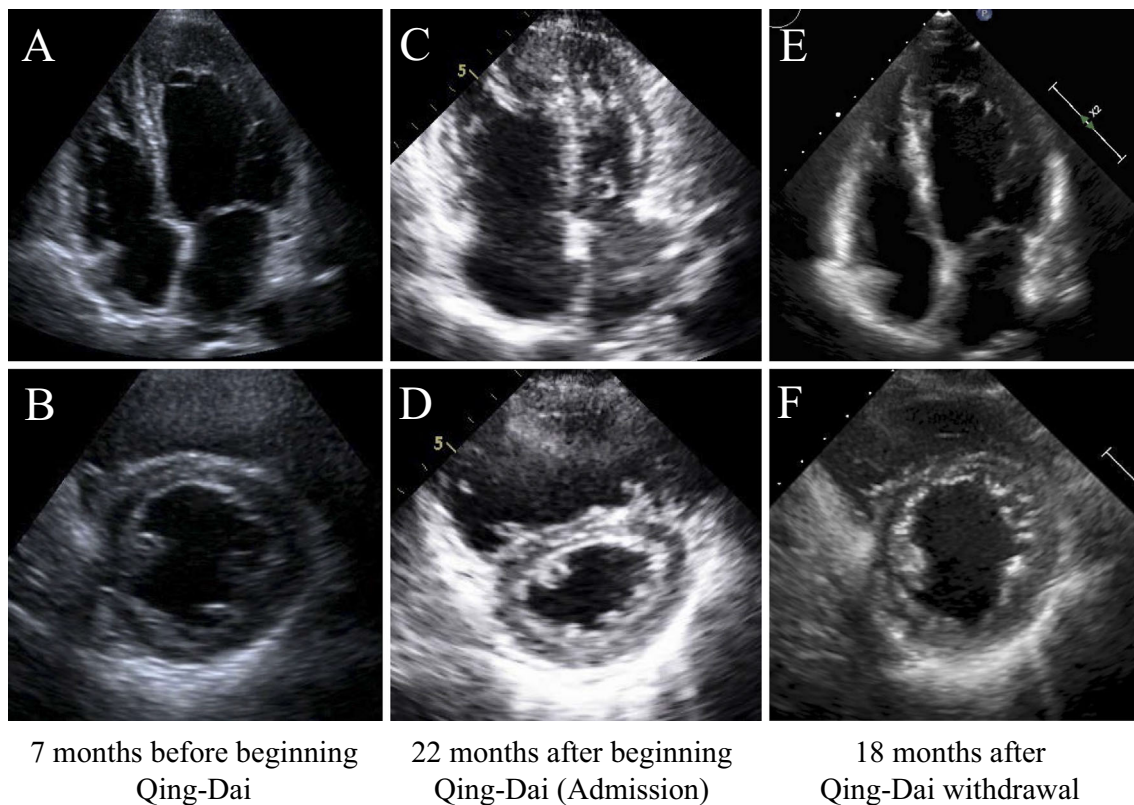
Echocardiography before Qing-Dai treatment, on admission due to worsening pulmonary hypertension, and 18 months after the discontinuation of Qing-Dai. A, B: The right atrial and ventricular chamber were of normal size and the trans-tricuspid pressure gradient was normal (22 mmHg) at 7 months before the initiation of Qing-Dai treatment. C, D: Right atrium and ventricular dilation, and deformity of the left ventricle on admission (22 months after the initiation of Qing-Dai treatment). E, F: Right atrial and ventricular dilation and deformity of the left ventricle disappeared at 18 months after the discontinuation of Qing-Dai and 6 months after the withdrawal of pulmonary hypertension-specific therapy.
